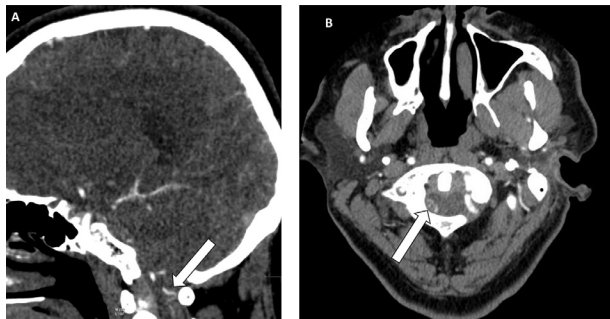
CT angiogram (A and B) shows early filling of serpiginous structures in the dorsal thecal sac (arrow) concerning for underlying spinal shunt. Compare to Fig. 6, post procedural exam.
